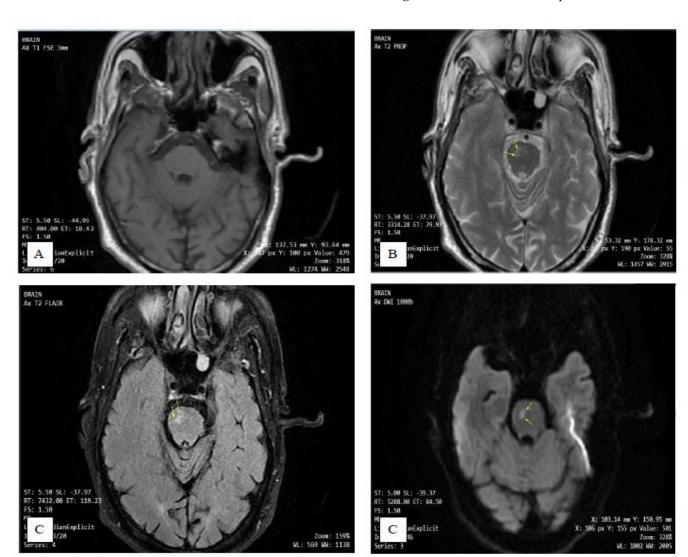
MRI brain of case no 5.
